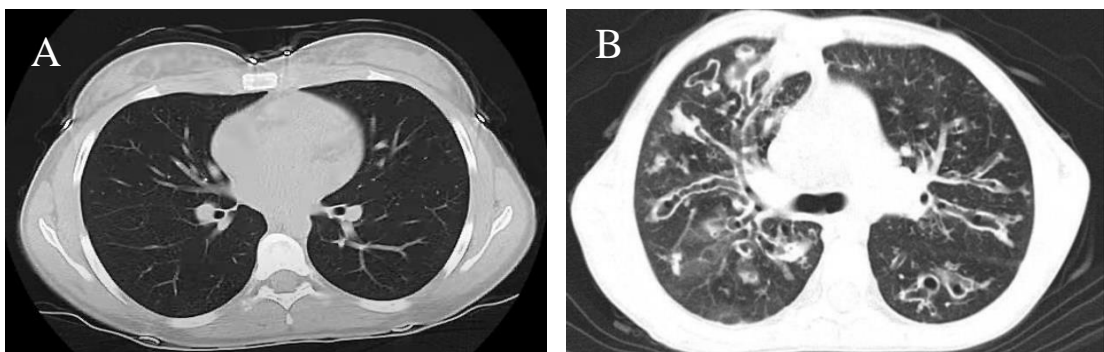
Chest computed tomography showing individuals with A) healthy lungs and B) cystic fibrosis lungs, showing peribronchial thickening and mosaic attenuation due to small airway disease.
